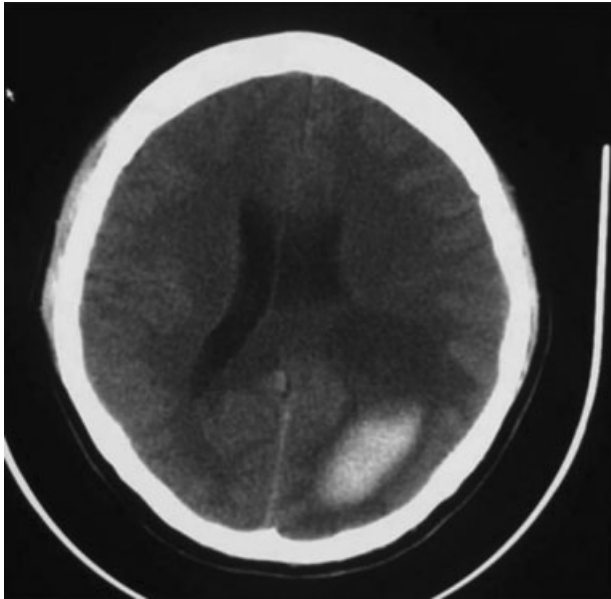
Computed tomographic scan showing a large left occipital intracerebral bleed.
